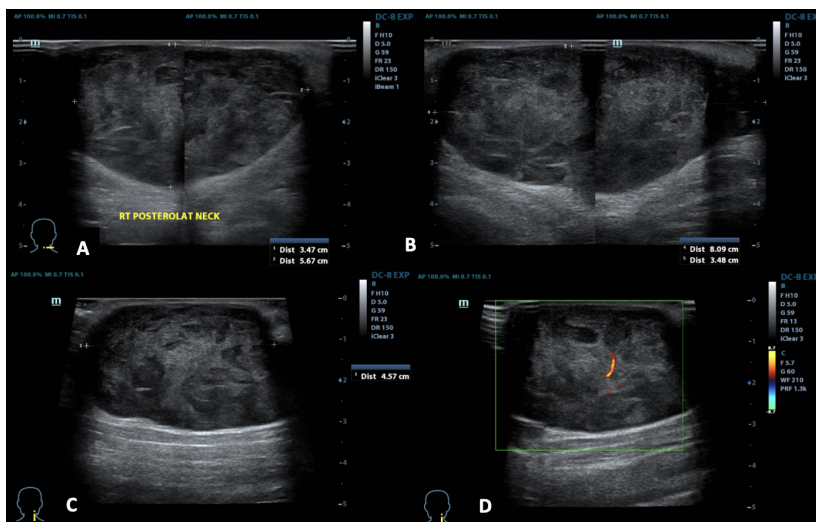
A-D: Ultrasound neck revealed a well-defined heterogeneous hypoechoic lesion seen within the subcutaneous layer of right posterolateral aspect of neck, measuring 3.5x8x4.6cm with minimal moving debris seen within. Minimal intral-lesional vascularity seen on Doppler, no calcification or intramuscular extension of the lesion. Presence of subcentimetre cervical lymph nodes with preserved fatty hilum, largest measuring 0.4cm in short axis
